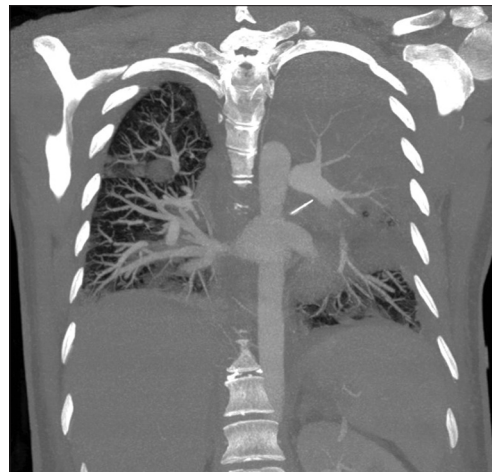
CT reconstruction picture showing foreign body obstructing the left main bronchus
